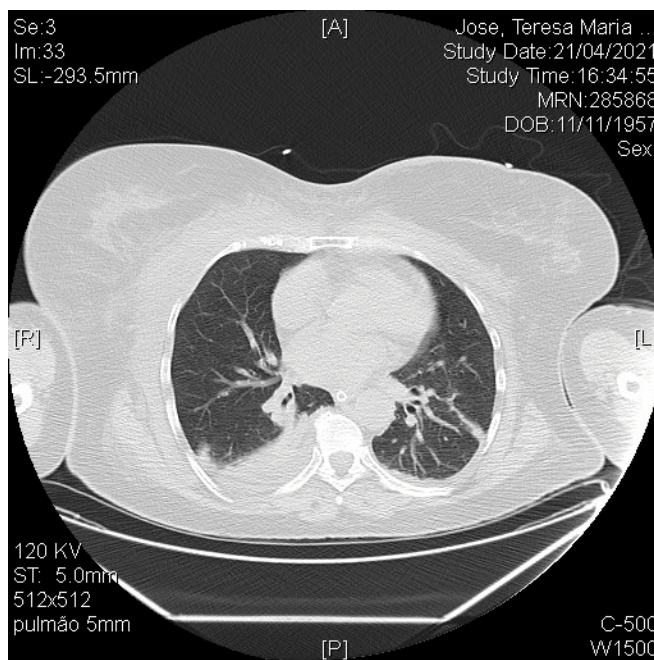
Day 1 post-operative: Thorax computed tomography showing edema mainly in the right breast and right pleural effusion
